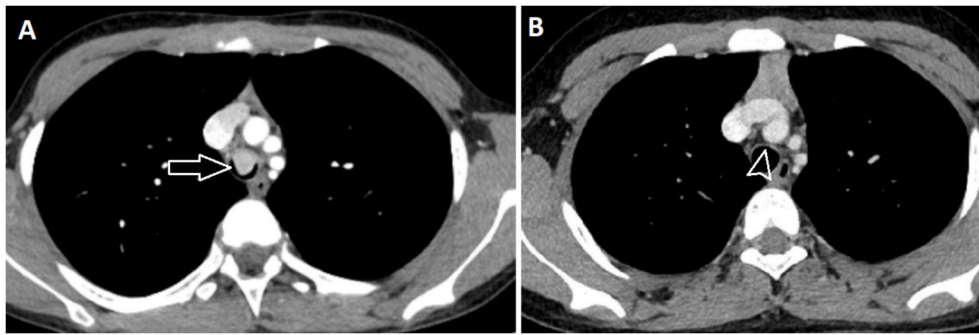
Chest computed tomography (CT) scans for the patient. An intratracheal mass was observed, with well-defined borders and homogeneous enhancement (A, arrow). Six months after surgery, no signs of recurrence were observed (B, arrowhead).
